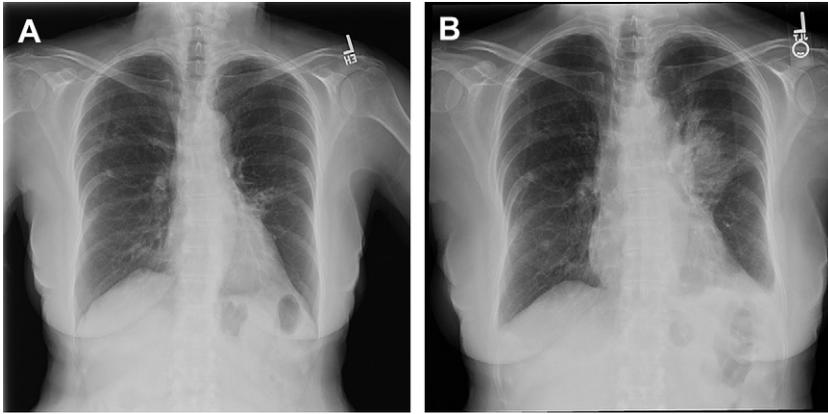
(A) Baseline P/A chest radiograph of a 70-year-old woman with bronchiectasis and MAC lung disease. (B) P/A chest radiograph of the same patient taken 4 weeks after the chest radiograph in A, and after acute onset of increased cough, sputum production, pleuritic chest pain, and fever.
